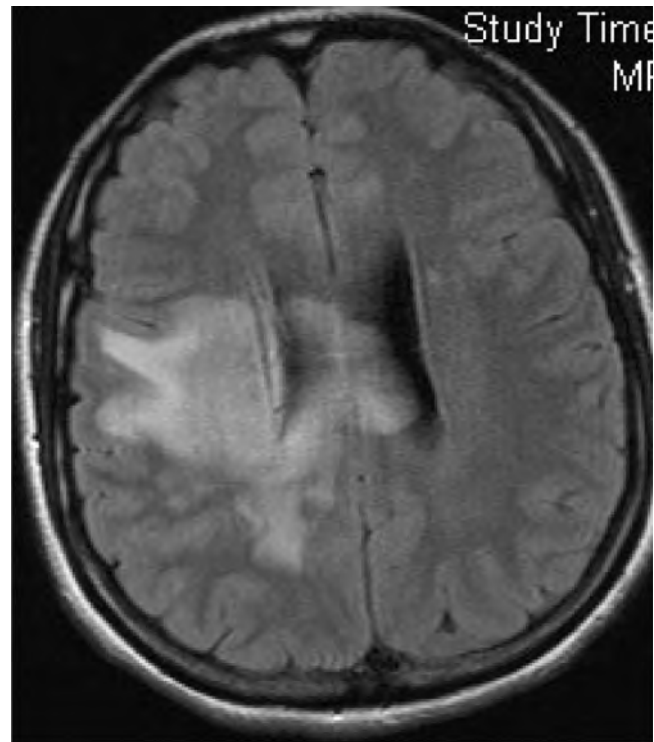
Large right temporo-parietal lesion with extension into the splenium of the corpus callosum (MRI T1W axial).
